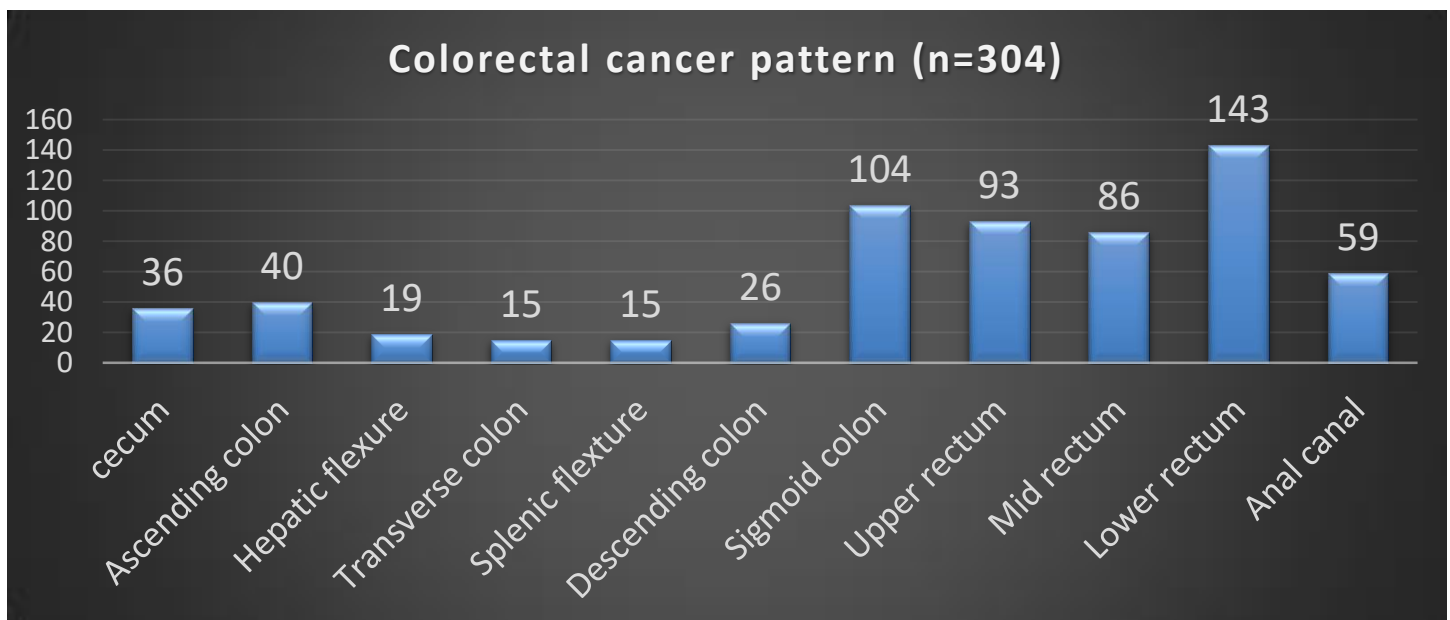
primary tumour site distribution of CRC (N=304) based on all imaging findings (US,CT,colonoscopy).
